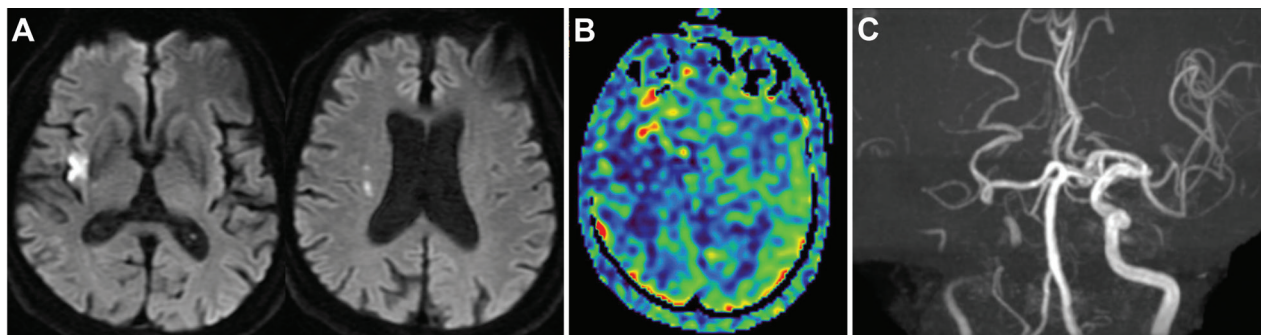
Case 2. Preoperative MRI-DWI (A)/ASL (B)/MRA (C). (A) A hyperintensity area was detected in the right cerebral hemisphere (DWI-ASPECTS: 9). (B) There was a reduction in blood flow in the right cerebral hemisphere. (C) The right internal carotid artery was slightly visualized, but the right middle cerebral artery was not. ASL: arterial spin labeling; ASPECTS: Alberta Stroke Program Early CT Score; DWI: diffusion-weighted imaging; MRA: magnetic resonance angiography; MRI: magnetic resonance imaging
